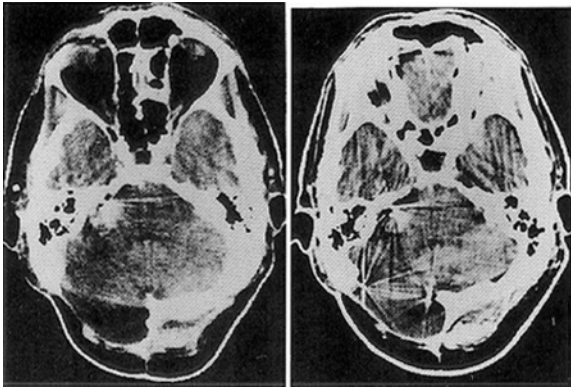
Case 6. Computerized tomography (CT) scan in a 61-year-old man with a large right-sided tumor. *Left:* Contrast-enhanced CT scan 13 years after surgery showing a small fragment of residual tumor. *Right:* A CT scan 4 years later showing no significant change.
